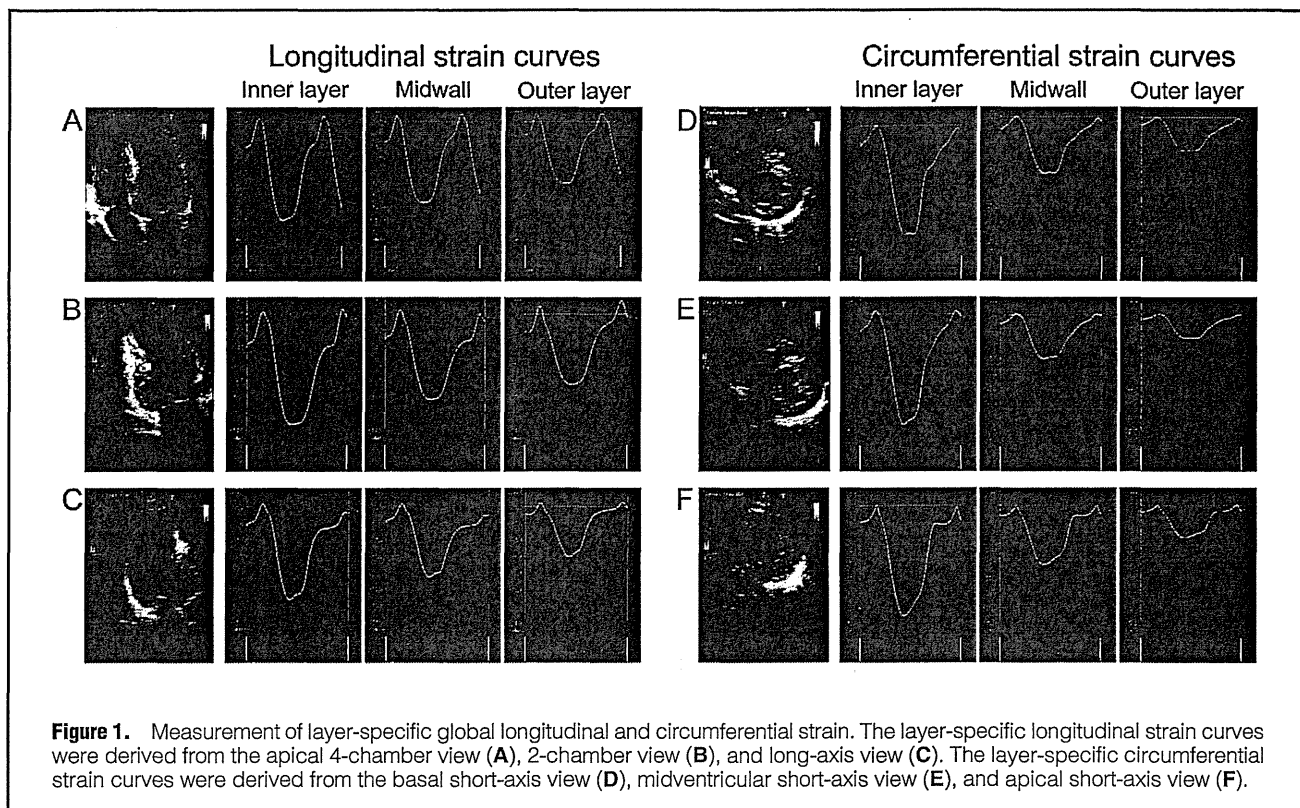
Measurement of layer-specific global longitudinal and circumferential strain. The layer-specific longitudinal strain curves were derived from the apical 4-chamber view (A), 2-chamber view (B), and long-axis view (C). The layer-specific circumferential strain curves were derived from the basal short-axis view (D), midventricular short-axis view (E), and apical short-axis view (F).
